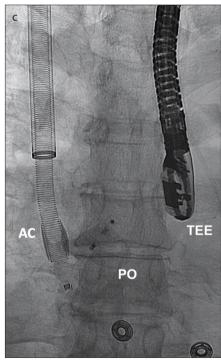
a–c. Midesophageal bicaval view at 95 degrees (a) and 98 degrees (b) transesophageal echocardiography and intraoperative fluoroscopy (c). Panel (a) demonstrates the deployment of the 30 mm Amplatzer Cribriform Septal Occluder (arrow) across the patent foramen ovale under echocardiographic guidance. The mobile mass (asterisk) in the inferior vena cava is seen adjacent to the delivery guide catheter. Panel (b) shows the AngioVac aspiration cannulae from the superior vena cava advancing inferiorly towards the mass (asterisk). Caution was given to avoid the Amplatzer Cribriform Septal Occluder (arrow). Panel (c) demonstrates echocardiographic guidance of the AngioVac cannula adjacent to the Cribriform Septal Occluder. LA, left atrium; RA, right atrium; IVC, inferior vena cava; AC, AngioVac cannulae; SVC, superior vena cava; PO, Cribriform Septal Occluder; TEE, transesophageal echocardiography..
